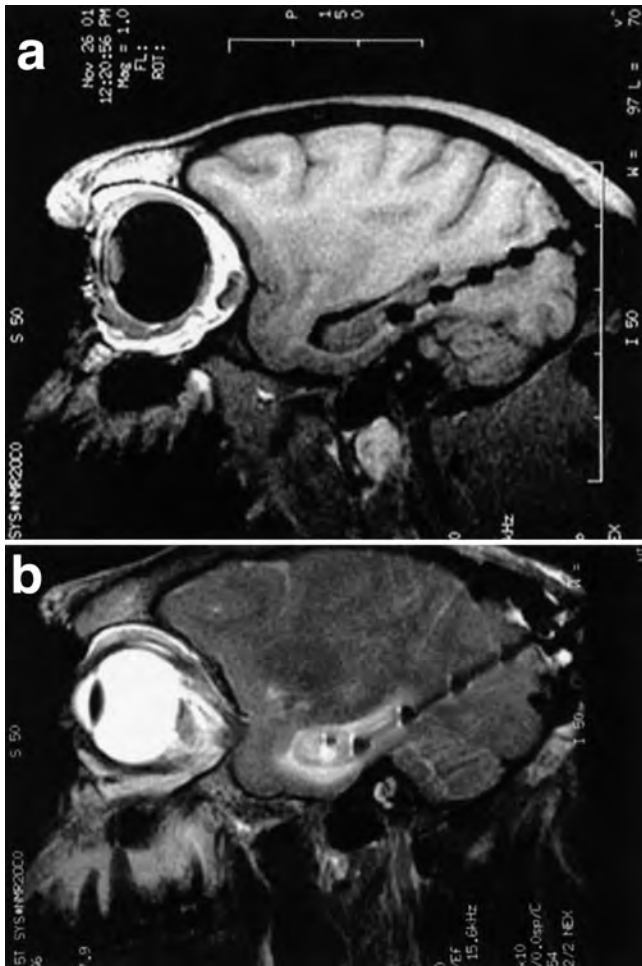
a: Parasagittal T<sub>1</sub>-weighted MR image demonstrating the catheter electrode as a black line with nodal enlargements at the electrode contacts. The apparent size of the electrodes is magnified on these images because of the metal within them. The tip of the perfusion catheter extends 4 mm beyond the deepest electrode and is not seen because of its small size (outer diameter 0.355 mm). b: Parasagittal T<sub>2</sub>-weighted image exhibiting the increased signal from the infusate (originating at the tip of the catheter), which displays the distribution of the infusate in the hippocampus and the adjacent white matter.
